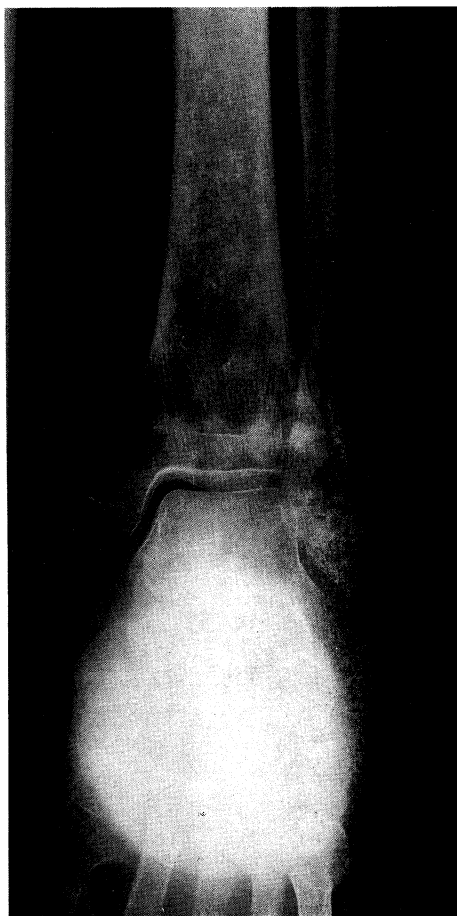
Bone X-ray showed osteosclerotic change in the left tibia fibula and tarsus.
